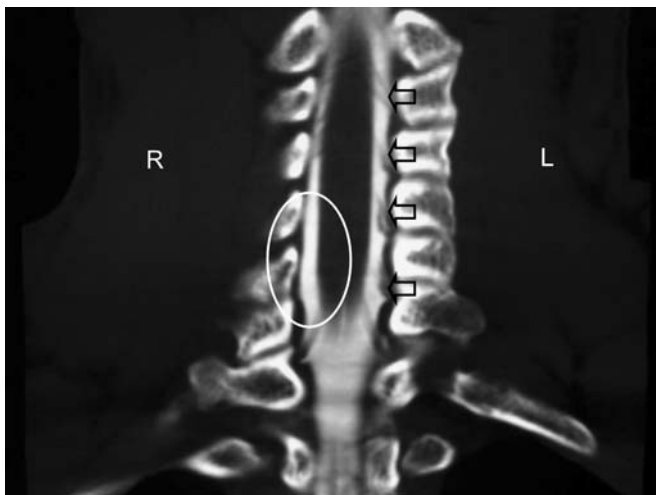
Nerve root avulsion. Coronal reconstruction of CT myelogram demonstrates normal visualized left-sided nerve roots (open arrows) at multiple levels with absent/partial nerve roots on the right C6 and C7 levels (open oval)
